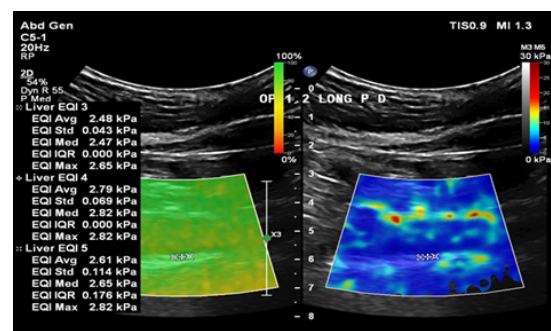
Ultrasound confidence map and elastography images of 2D SWE measurements from the posterior wall of the infra-renal abdominal aorta. (Reprinted by permission of Elsevier from "Reproducibility of ultrasound 2D shear-wave elastography on abdominal aortic wall" by Alsayegh et al. *Ultrasound in Medicine and Biology*, 2024;50:S30-S31, World Federation for Ultrasound in Medicine and Biology Congress).
